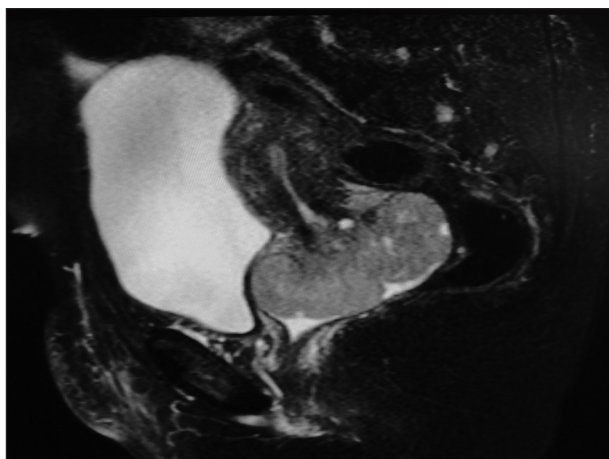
T1 Weighted magnetic resonance imaging showing large cervical mass
